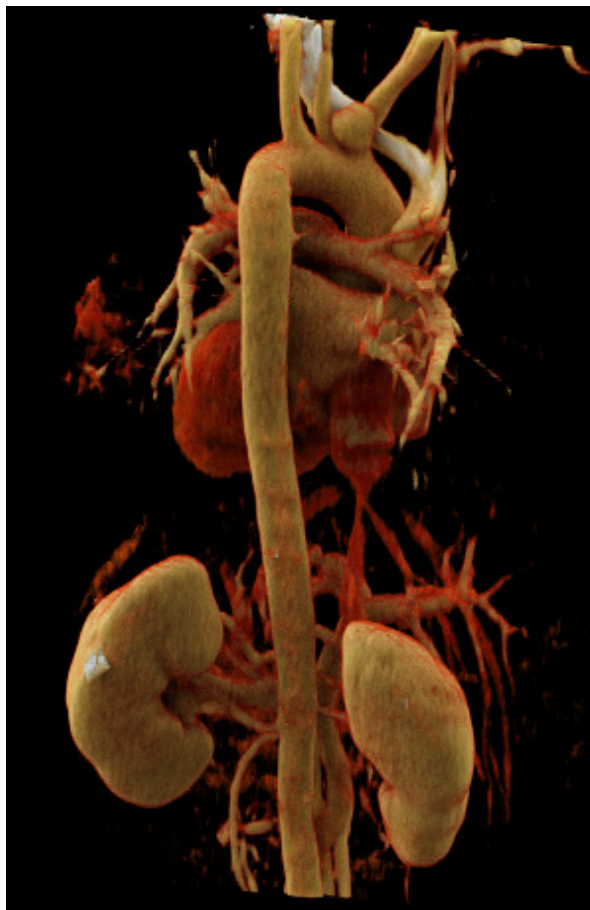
Computed tomographic image shows a 3-dimensional reconstruction of traumatic pseudoaneurysm at the proximal brachiocephalic artery (posterior view).
